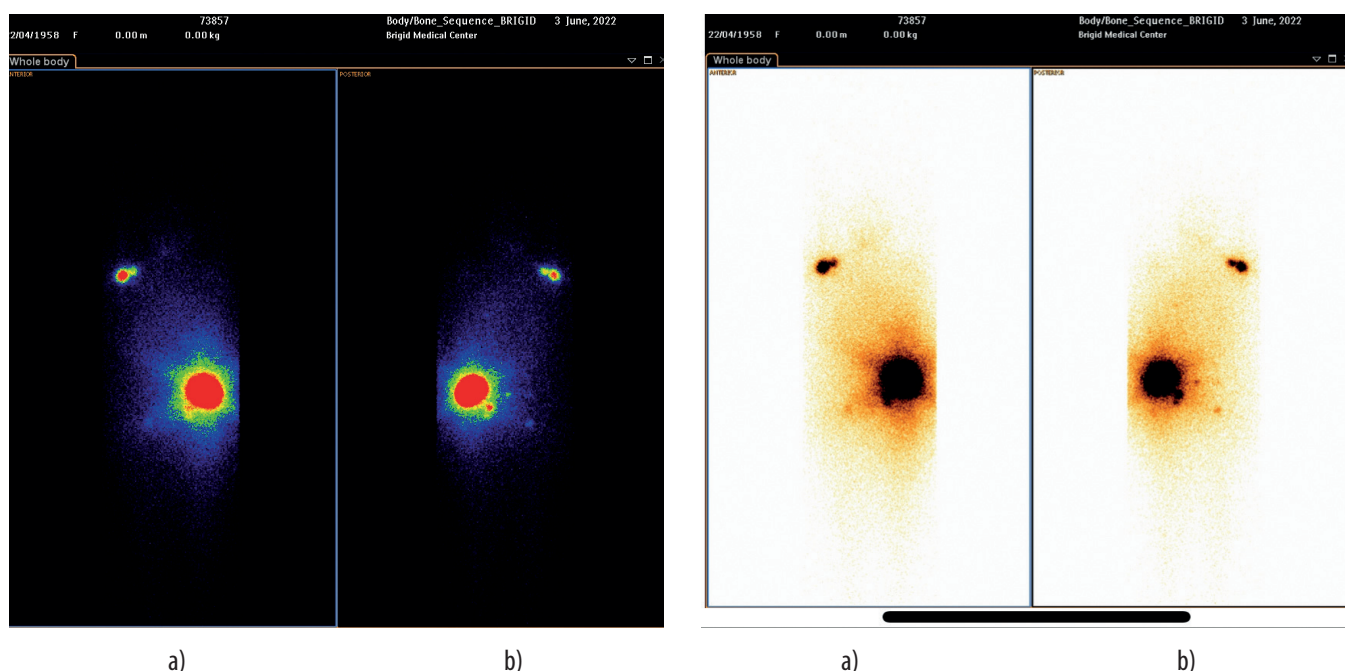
Response to radioiodine therapy of patient M. with TC after the first course. On the scintigrams in the front (a) and back (b) projections, several «hot spots» of fixation of the radiopharmaceutical drug are visualized on the neck and shoulder on the right, pelvic bones, in the left and right lung by post-therapy whole-body scans on day 7 after the initial administration of 5995 MBq  $^{131}\text{I}$  sodium iodide. The SPECT image shows functionally active metastases of the TC (in the color image – Fig. 3, in the black and white image – Fig. 4).
